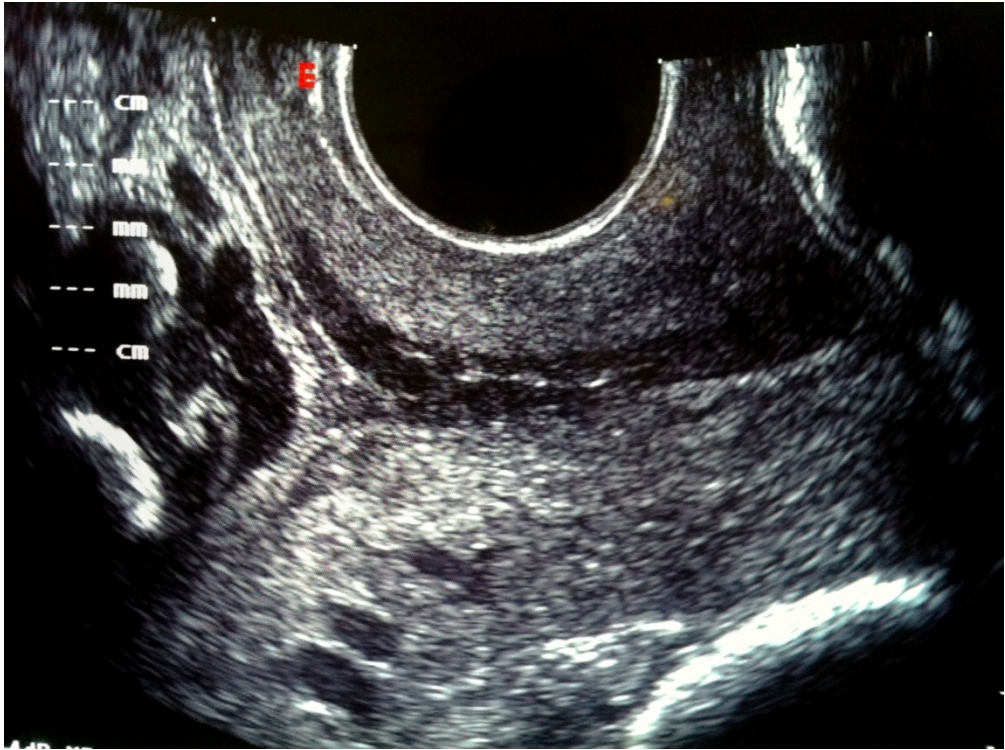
Transvaginal ultrasound assessment of hyperechoic membranes with the fetus in breech presentation
